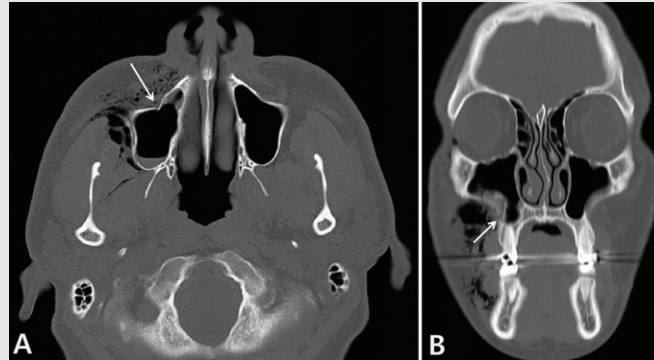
Radiographs taken during the initial examination. A) A fracture (arrow) of the anterolateral wall of the right maxillary sinus with an air-fluid level at the right maxillary sinus on facial bone computed tomography (CT) (axial view); B) facial bone CT (coronal view)
